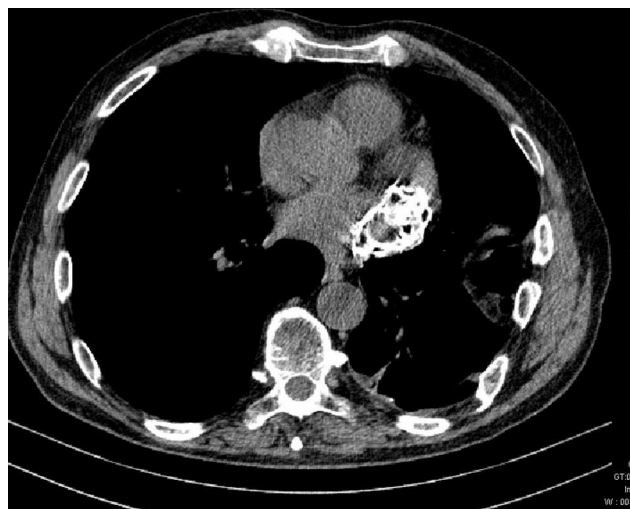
Thoracic computed tomogram showing a large lesion with irregular calcifications.
